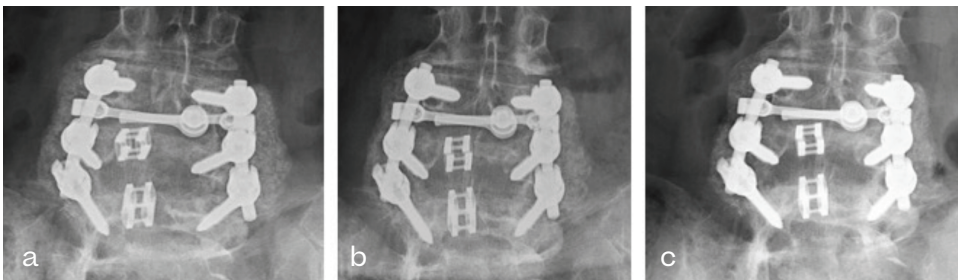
Comparative AP X-ray radiographs of patient #15 at 3 months (a), 6 months (b), and 12 months (c) following L4-5, L5-S1 posterolateral fusion. There is notable progression of posterolateral bony fusion over the 12-month period with robust solid posterolateral bony fusion at 12 months.
